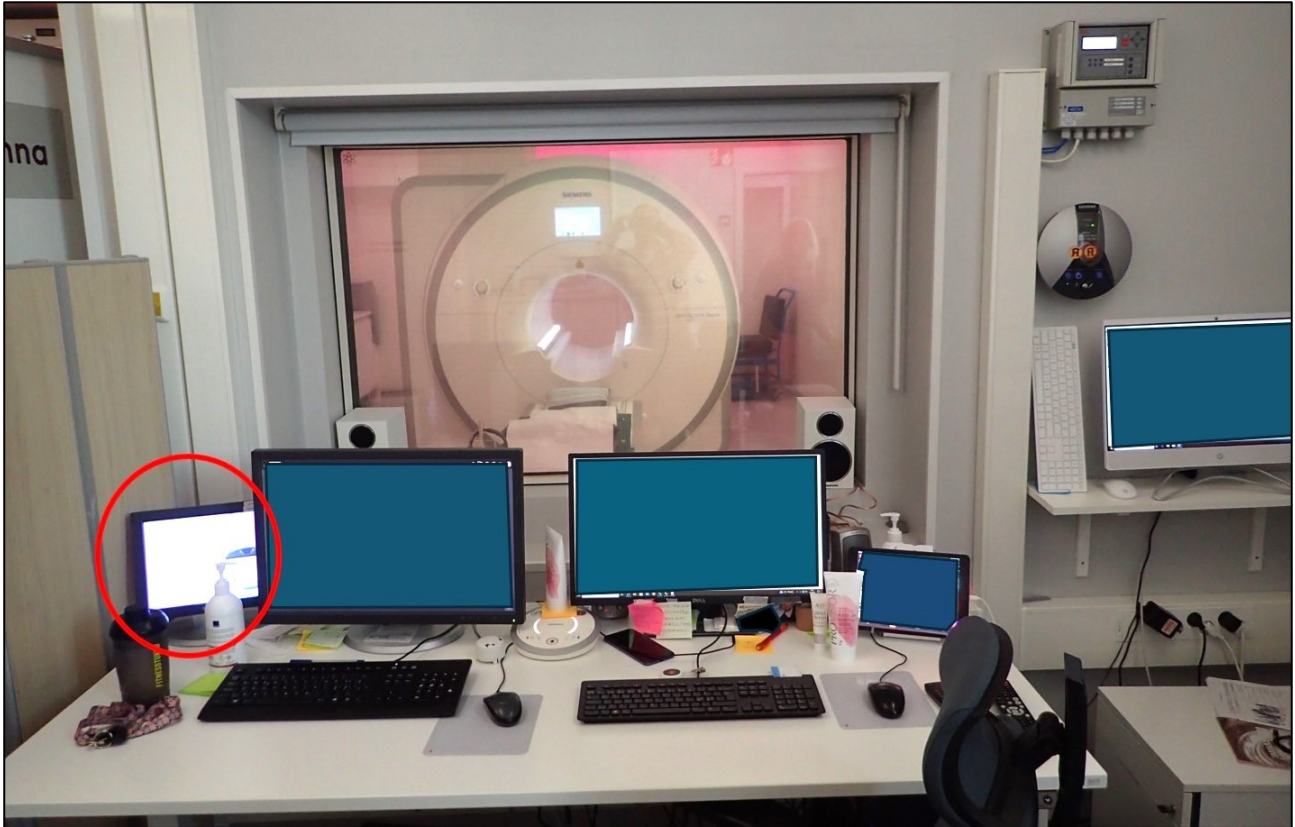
The photo shows the control and monitoring point for the MRI scanner. The red circle on the left marks the monitoring camera screen at one end of the MRI scanner. The screens shown in the photo have been blurred. (Photo: SIAF)
